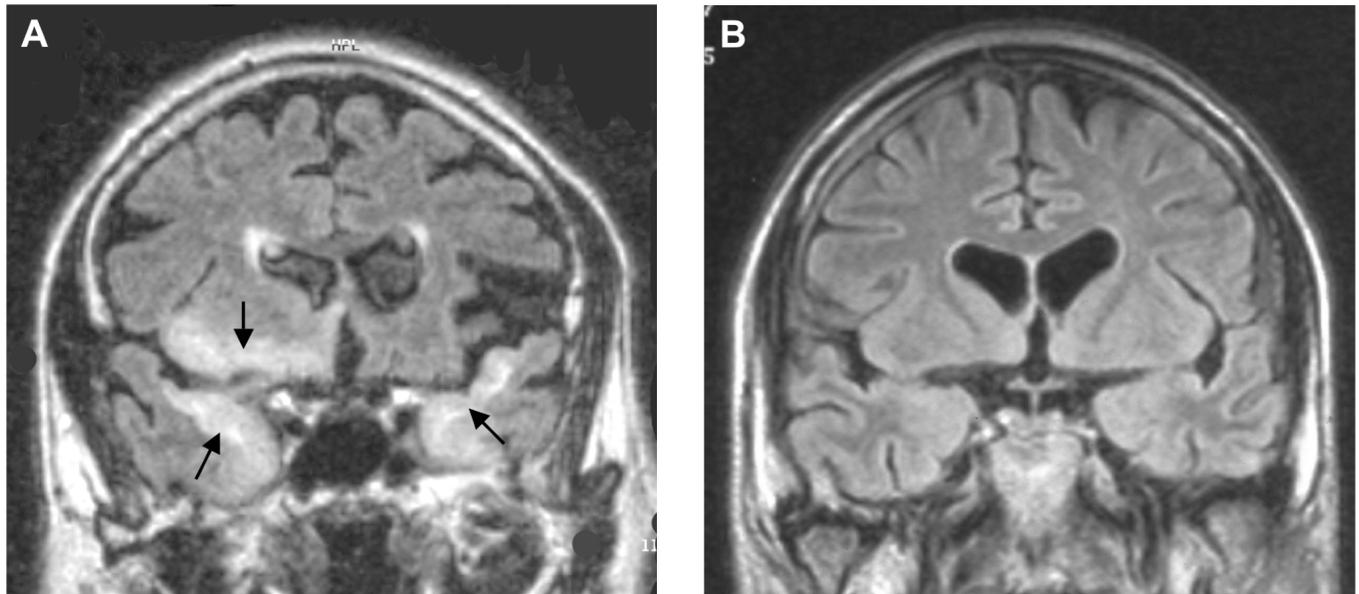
Coronal fluid-attenuated inversion recovery (FLAIR) MRI scan demonstrates: bilateral involvement of medial temporal lobes and right orbitofrontal region (arrows) in one case of HSV-1 encephalitis (A), and normal image of one age-matched control (B).
